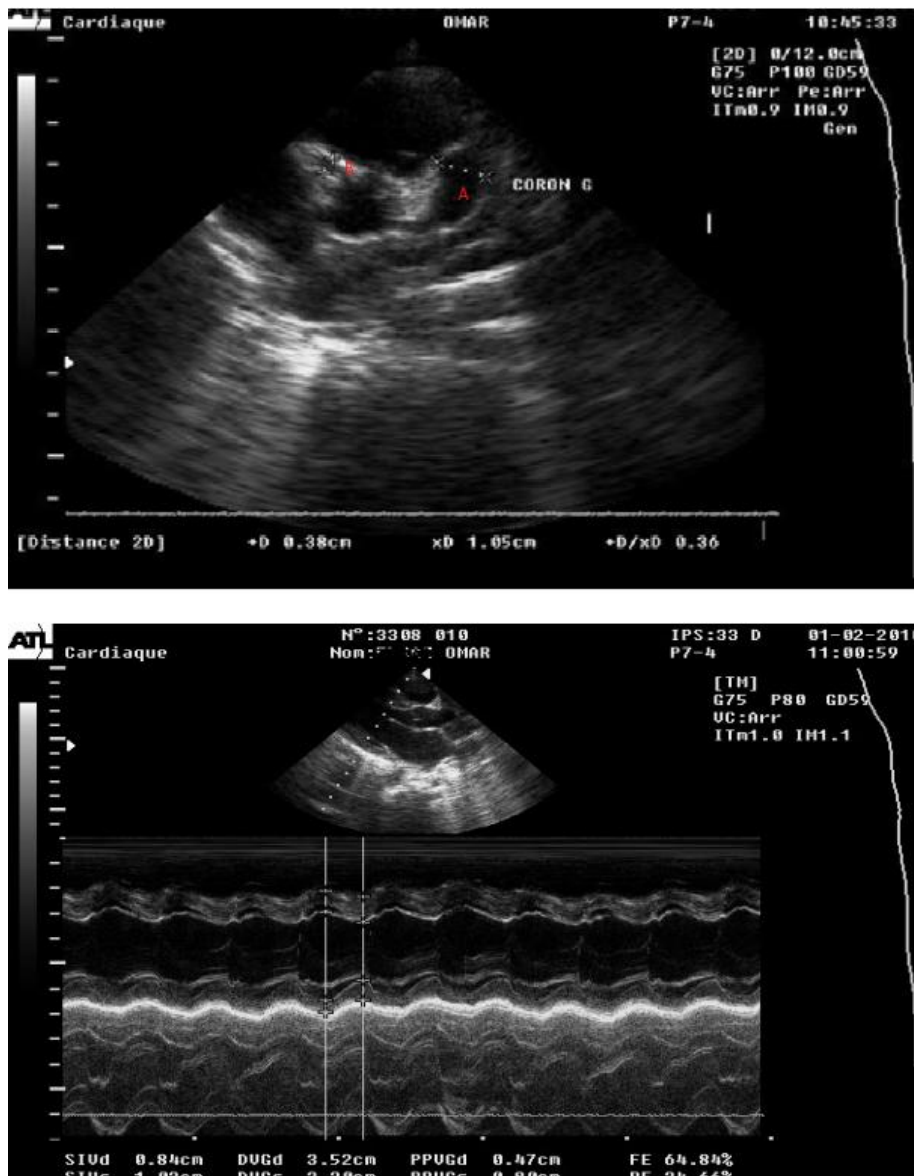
2D and TM Echocardiography of a 3-year-old child, showing (A): a 10 mm aneurysm of the left coronary artery, (B): right coronary artery: 4.9 mm, and (C):good VG function (Photo Pediatric Service 4 Rabat Children’s Hospital)
